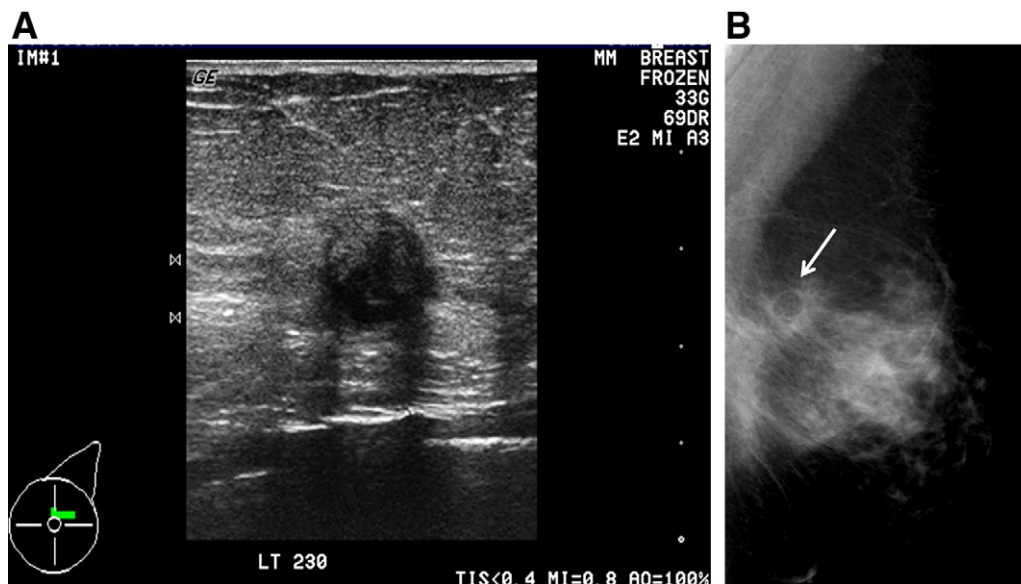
Transverse sonographic image, showing heterogeneous mass with irregular posterior shadowing. A 61-year-old patient with a history of breast reduction, presented with painful left breast (A). Mediolateral oblique mammographic image (B), showing a lucent lesion, which correlates to the ultrasound finding (arrow). Surgery was performed because of symptoms, and pathology confirmed fat necrosis.
